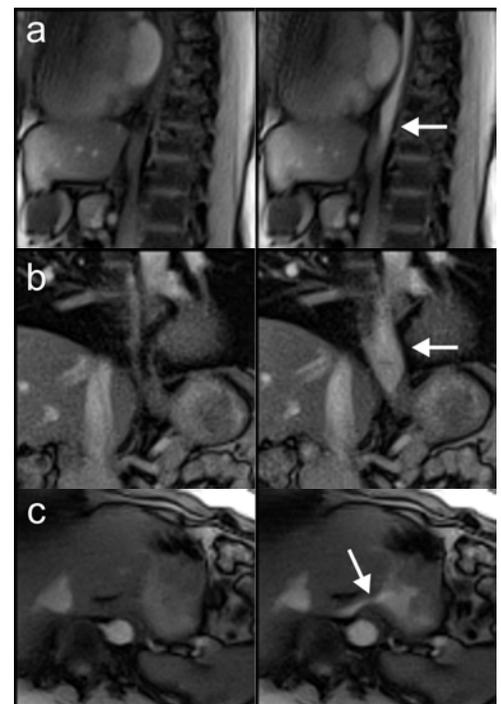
Real-time MRI of esophageal function during swallowing in (a) sagittal, (b) oblique coronal, and (c) oblique transversal planes. Arrows indicate the bolus transport.
